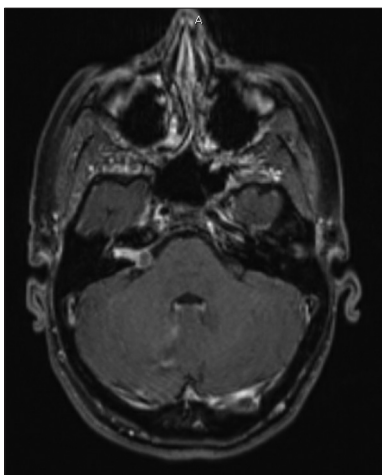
Pre-operative axial T1-weighted magnetic resonance imaging with contrast demonstrating a 1.7 cm enhancing lesion within the right internal auditory canal extending into the right cerebellopontine angle cistern.
